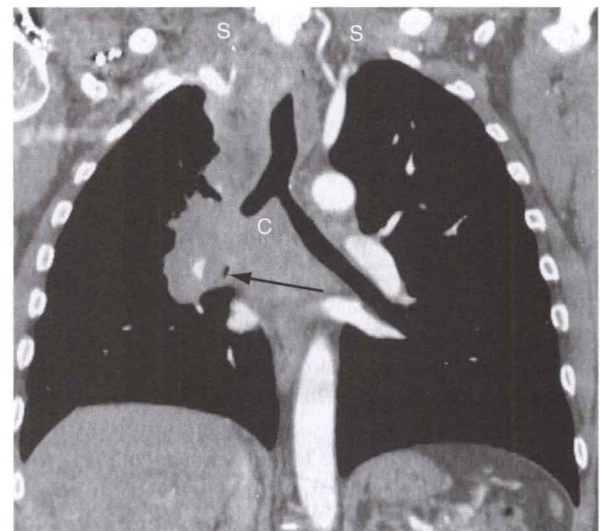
Newly diagnosed small cell lung cancer in a 52-year-old man. Coronal contrast-enhanced chest CT scan shows conglomerate lymphadenopathy involving the right hilum, subcarinal region (C), and bilateral paratracheal regions extending to involve the bilateral supraclavicular regions (S). This process obliterates the right main bronchus and significantly narrows the right lower lobe bronchus (arrow). Note that the primary cancer cannot be differentiated from the extensive lymphadenopathy.
